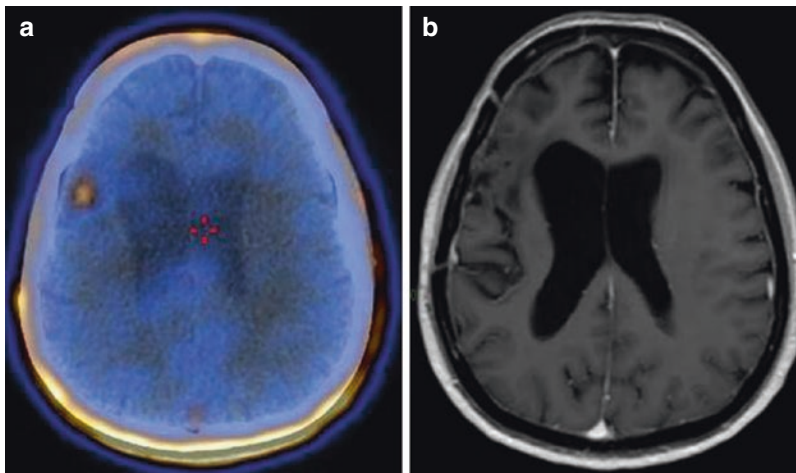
In a patient previously submitted to surgical excision of a low-grade glioma, axial ^{18}F -FMC PET/CT view (a) shows pathologic tracer uptake in the postsurgical lacunar area in right temporal region. No meaningful
